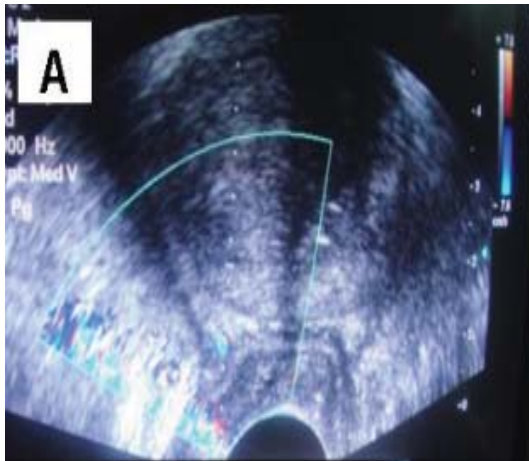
TRUS with Doppler showing location of periprostatic nerve plexus.
